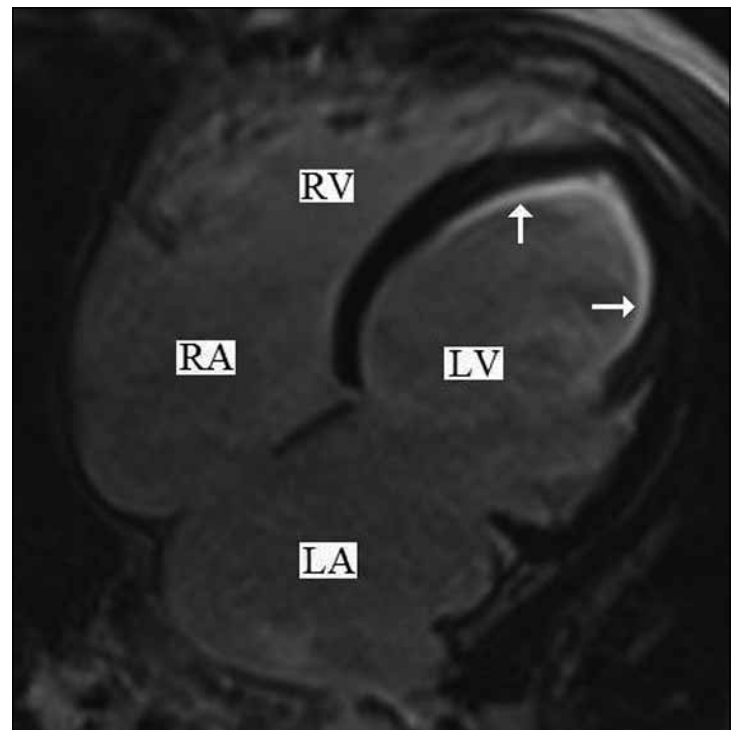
Cardiac magnetic resonance imaging scan showing delayed gadolinium enhancement in an apical endomyocardial distribution (white arrows). Bi-atrial dilatation was marked. LA = left atrium; LV = left ventricle; RA = right atrium; RV = right ventricle.
